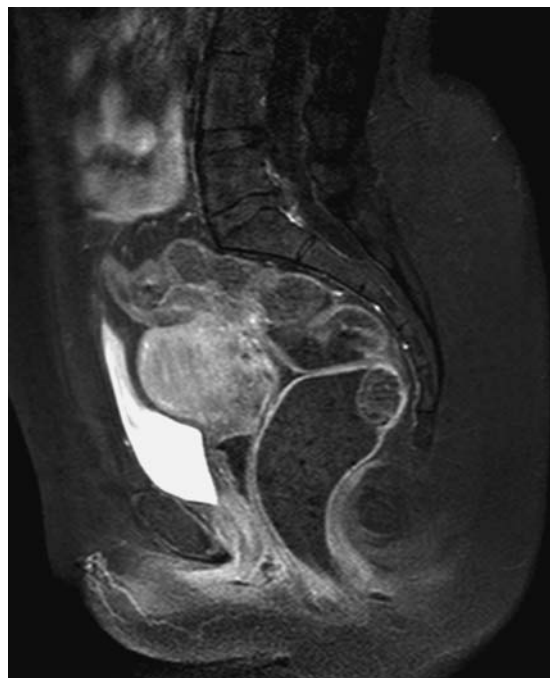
Rectal stenosis due to circumferential endometriotic nodule (MRI examination, T1 sequence).
